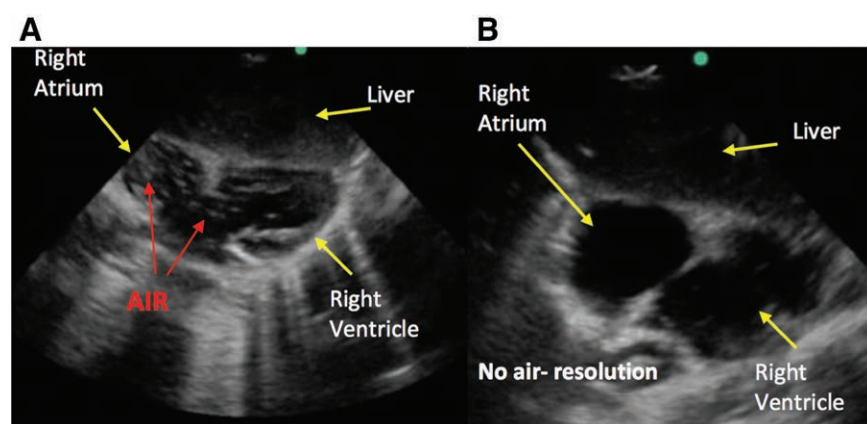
Images in Anesthesiology: Air Embolism during Cardiac Catheterization and the Role for Anesthesia Use of Bedside Ultrasound
